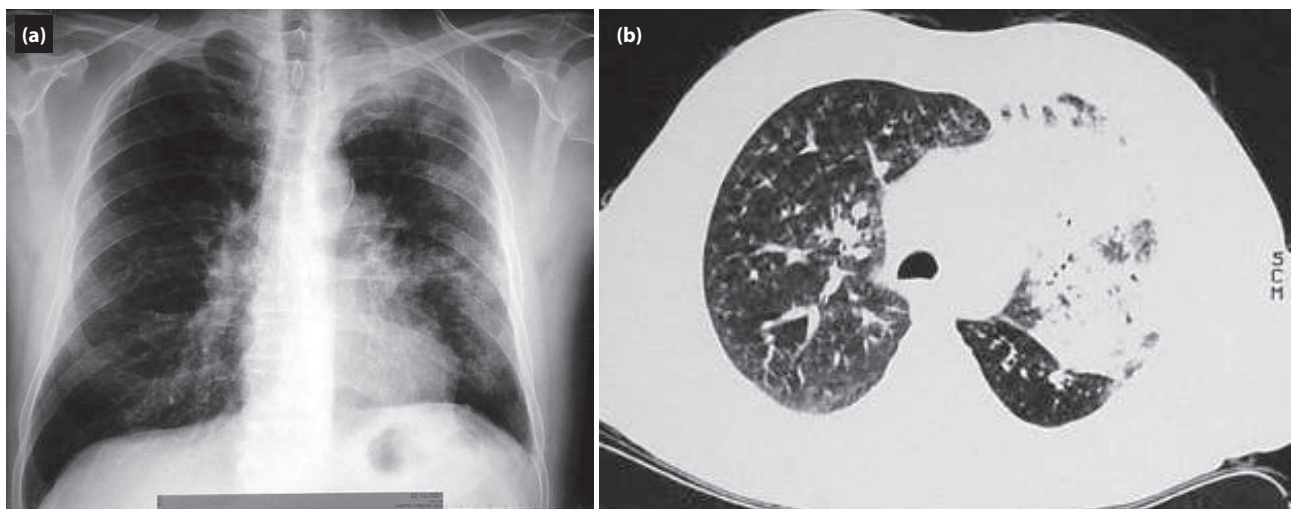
(a) Chest x-ray reveal multiple diffuse opacities mainly in the left lung. (b) Chest computed tomography (CT) scan reveal bilateral diffuse mixed ground glass and reticular opacities, and solid like consolidation of the left lung.
